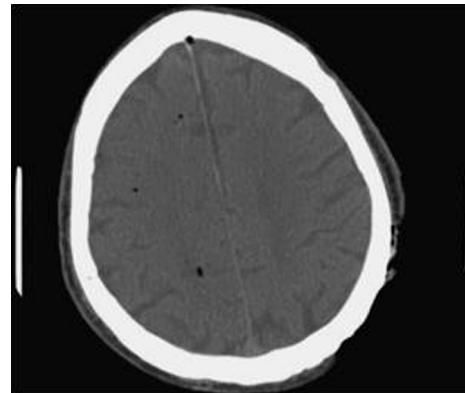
A computed tomography scan reveals air (dark circles) within vascular structures in the brain parenchyma (from patient shown in Fig 2). Reproduced with permission from Goldman et al.⁶
